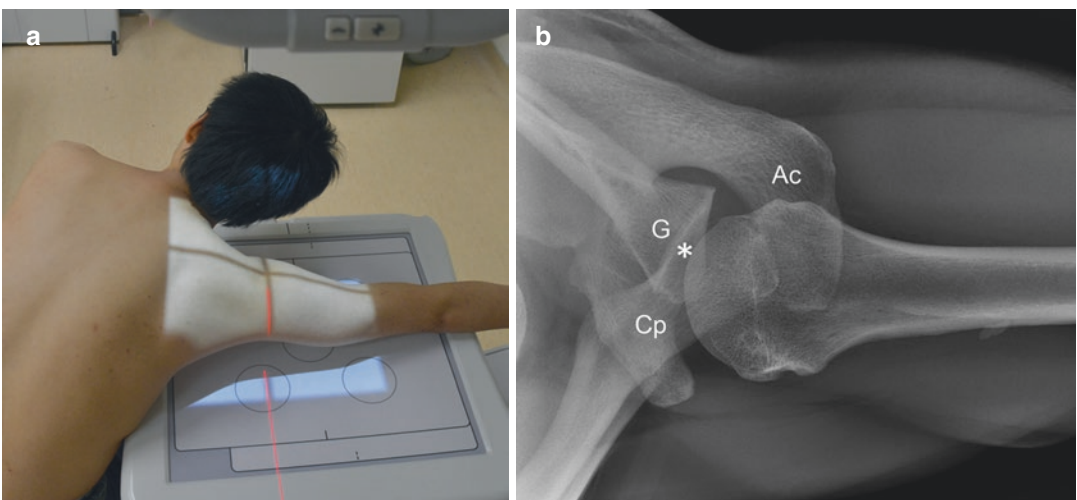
(a) Radiographic positioning for axillary view. (b) Normal axillary view showing coracoid process (Cp), acromion (Ac), glenoid (G), and glenohumeral joint (*) which is almost but not quite in profile
